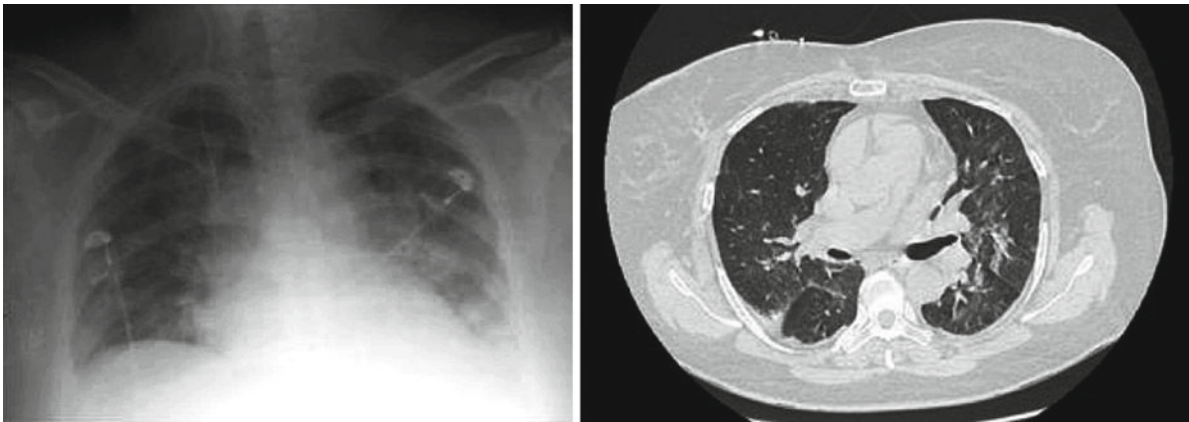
The chest X-ray revealed bibasilar interstitial infiltrates and a subnormal cardiothoracic ratio. CT disclosed ground-glass opacities, septal lines, and bilateral pleural effusion
